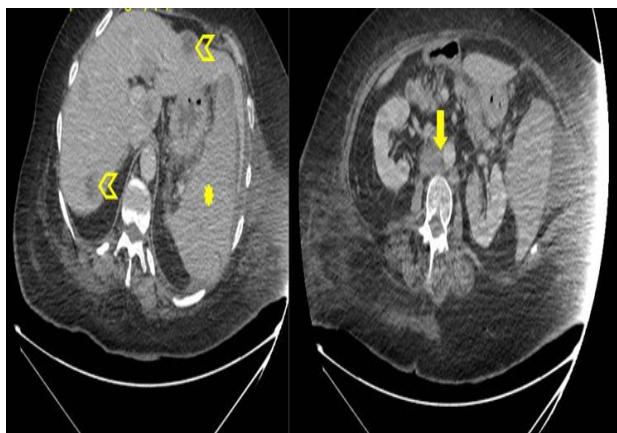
Axial CT Abdomen showing Liver lesions, aortocaval nodes (solid arrow) and splenomegaly (*).
